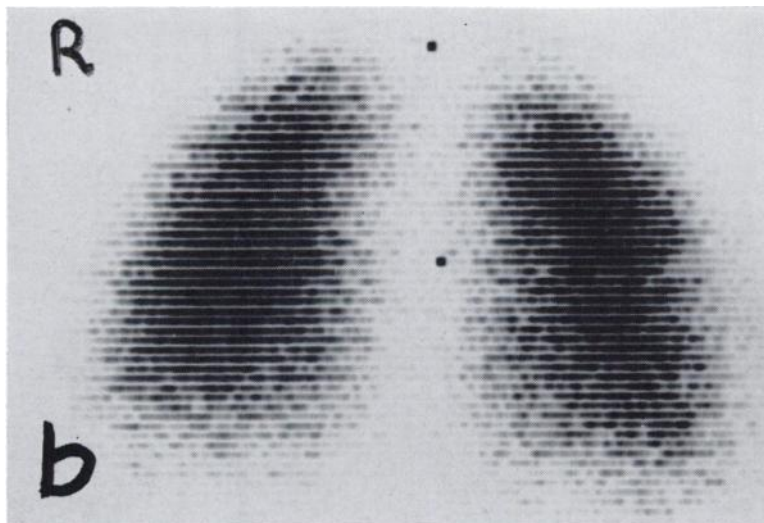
Posterior lung scan using ^{131}I albumin aggregates on the day of the chest x-ray showing slight residual scar in the left mid lung laterally, but otherwise normal.
